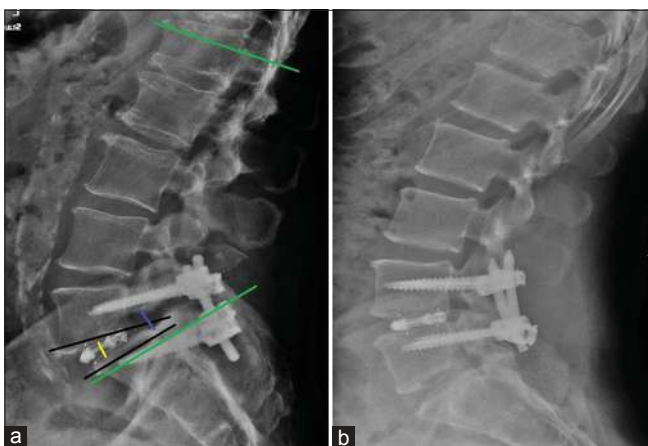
(a) Measuring variable angles and neural dimensions: (1) Red line: neuroforaminal height. (2) Blue line: Disc height. (3) Yellow line: Focal and Global Cobb angle, (b) Follow-up X-ray
